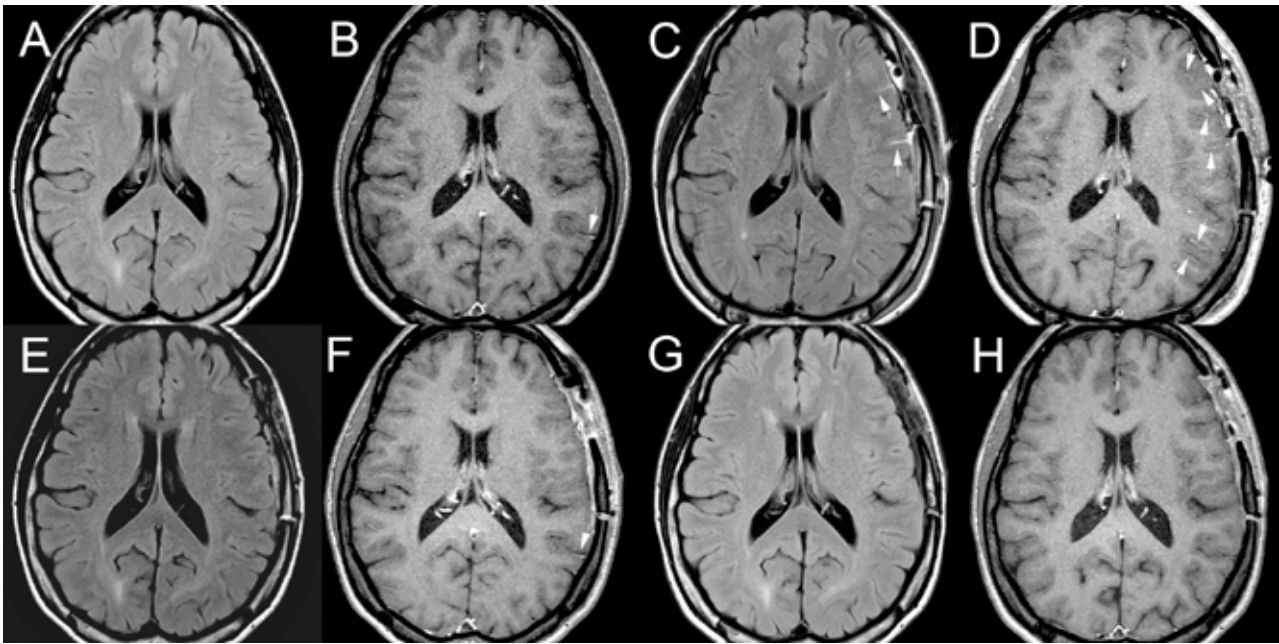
Postoperative changes on magnetic resonance imaging (MRI)/fluid attenuation inversion recovery (FLAIR) (A, C, E, G) and MRI/gadolinium-enhanced (Gd) vessel wall imaging (VWI) (B, D, F, H) in a 54-year-old female with moyamoya disease who underwent left bypass surgery. A, B: Preoperative MRI. MRI/FLAIR shows no apparent sulci hyperintensity (A), while MRI/Gd VWI demonstrates linear enhancement in the left temporal sulcus (B). C, D: MRI 3 days after surgery. MRI/FLAIR shows hyperintense lesions in the sulci of the left frontal lobe (C). MRI/Gd VWI reveals linear enhancements in the sulci of the left frontal, parietal, and temporal lobes (D). E, F: MRI 20 days after surgery. MRI/FLAIR shows the disappearance of hyperintensity in the sulci (E), while MRI/Gd VWI still demonstrates a linear enhancement in the left temporal lobe (F). G, H: MRI 3 months after surgery. Both MRI/FLAIR (G) and MRI/Gd VWI (H) indicate the disappearance of the postoperative changes. The white arrow indicates sulci hyperintensity or sulci enhancement.
